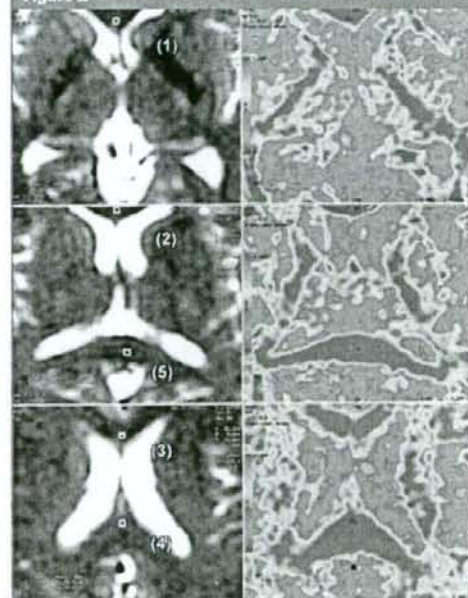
Transverse T2-weighted MR images (left, $b = 0$ sec/mm²) and corresponding FA maps (right, $b = 1000$ sec/mm²) in patient with OCD (>17 000/ >115.6 , 4-mm section thickness). ROIs are drawn in rostrum (1), genu (2), rostral body (3), isthmus (4), and splenium (5) of CC. Right: Colors, demonstrated by using Functool 2.2.49 software, indicate various grades of white matter anisotropy. Blue indicates low grade of white matter anisotropy, and red indicates high grade of white matter anisotropy.
